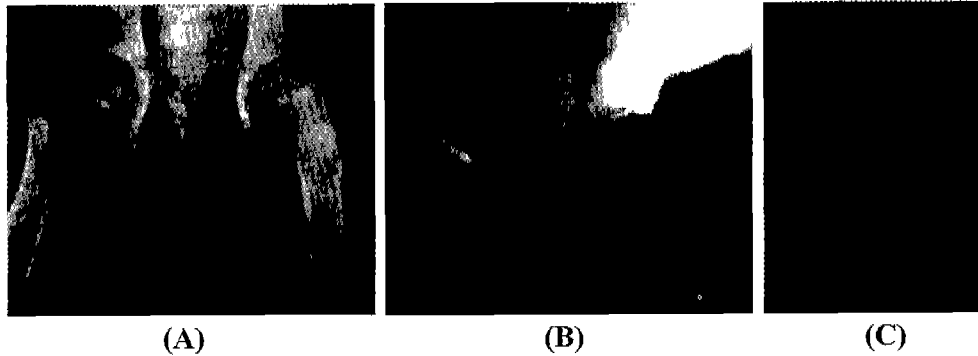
Radiography of femur (A), radius and ulna (B) on day 7. There were sclerotic change of proximal metaphysis (A) and distal metaphysis near the physal cartilage in femur and distal metaphysis in tibia (B). Abnormal radiolucent line was observed in metaphysis of radius and ulna (C).
